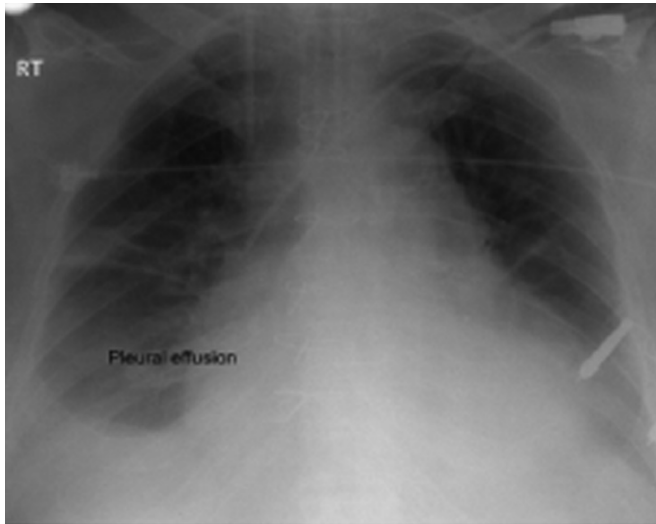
Chest radiograph showing the right-sided pleural effusion.
